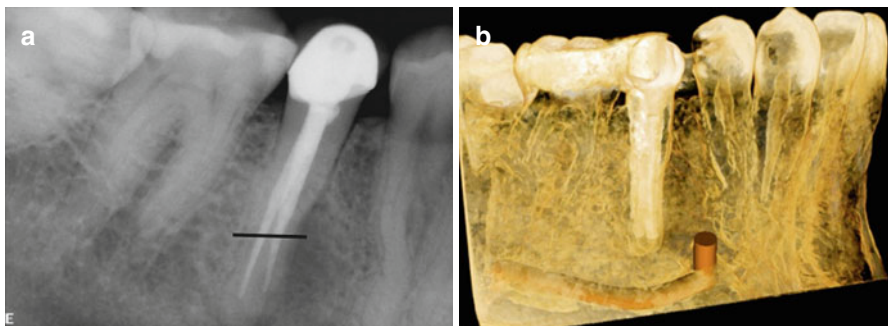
Periapical radiograph of tooth #29 that was referred for apical microsurgery (a). The line corresponds to the level of the axial view in (c). Note the C-type-shaped canal (*black arrow*). 3D rendering demonstrating the relationship and proximity of the inferior alveolar nerve (IAN) and mental foramen to the apex of tooth #29 (b). Axial view of the apical 1/3 demonstrating the extent of the periapical defect (c). Coronal view demonstrating the relationship and the proximity of the IAN canal (d). 3D rendering demonstrating the relationship and the proximity of the IAN to the periapical defect as well the apex of tooth #29 (e)
